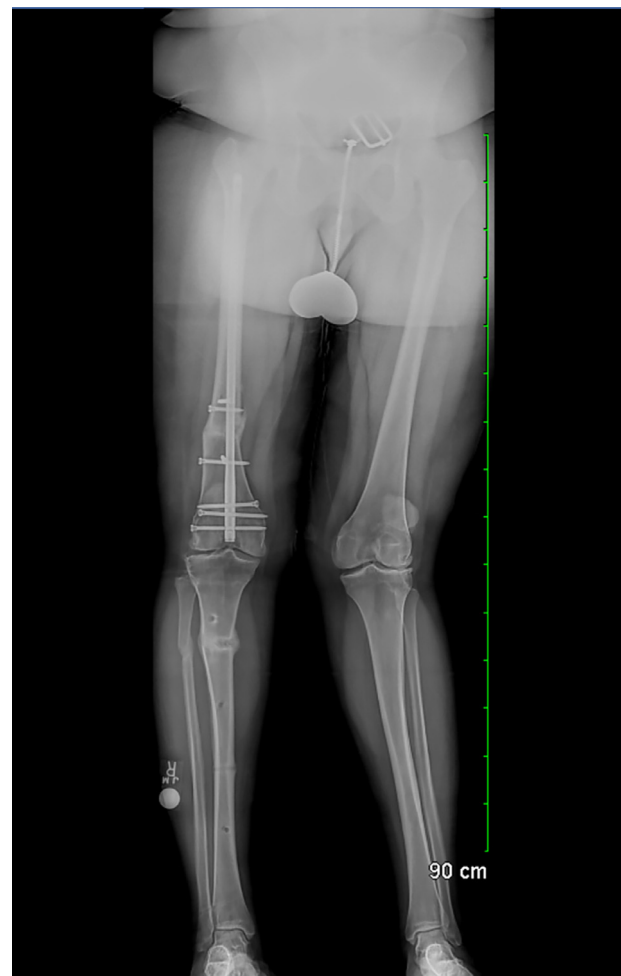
AP radiograph of patient with a congenital malalignment. The left side has external rotation and valgus deformity of the distal femur and an internal rotation with valgus deformity with limb length inequality of the tibia. The contralateral side had similar deformities and the femur was corrected with a static intramedullary nail while the tibia was corrected with a hexapod external fixator into mild overcorrection in varus for lateral sided arthritis that was worse than that on the left.
